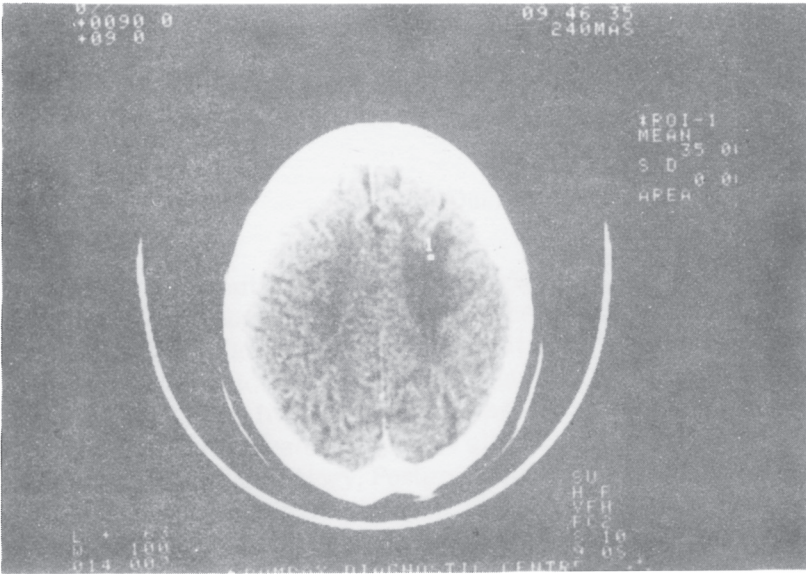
Pre contrast axial CT scan of a patient showing a low attenuation area (oedema) in the right fronto-motor region following a recent focal epileptic seizure in the left limb.
